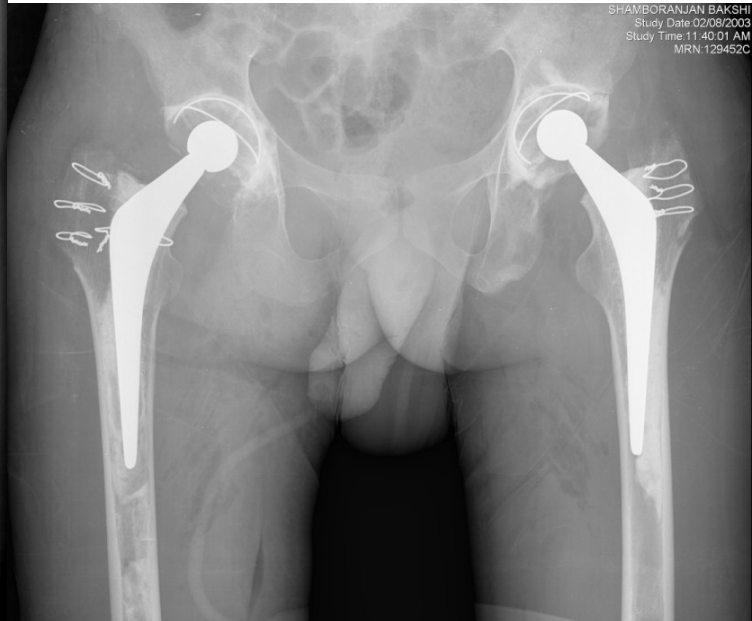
Immediate post-op and follow-up radiographs of Exeter hips with Engh second degree proximal femoral resorption
